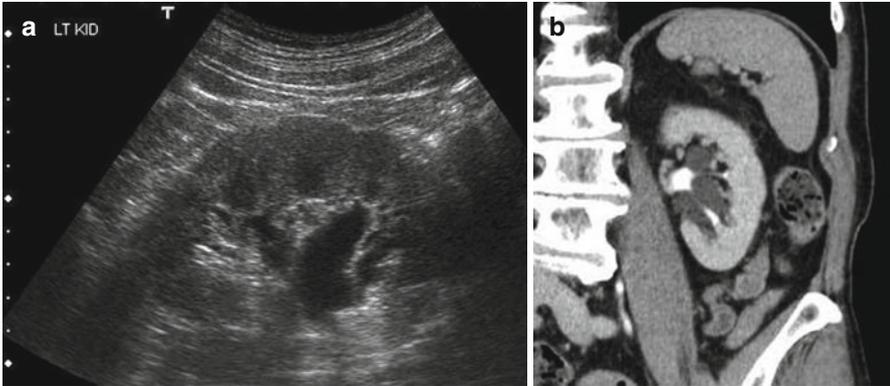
The ultrasound image (a) suggests a hydronephrosis. The coronal CT urogram (b) shows the opacified normal pelvicalyceal system running between the parapelvic cysts
